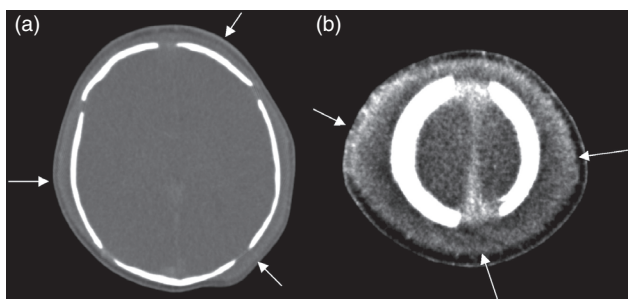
Large bilateral subgaleal hematomas (arrows) on CT with (a) bone and (b) soft tissue algorithms.
